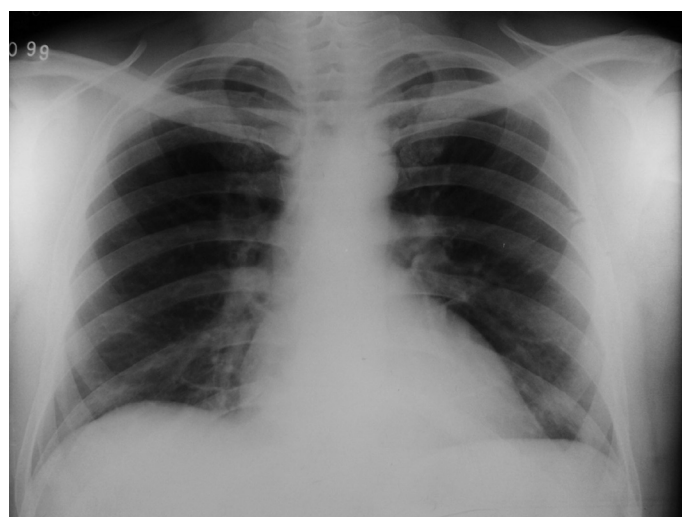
Chest radiograph seven months after the tumor eradication.
